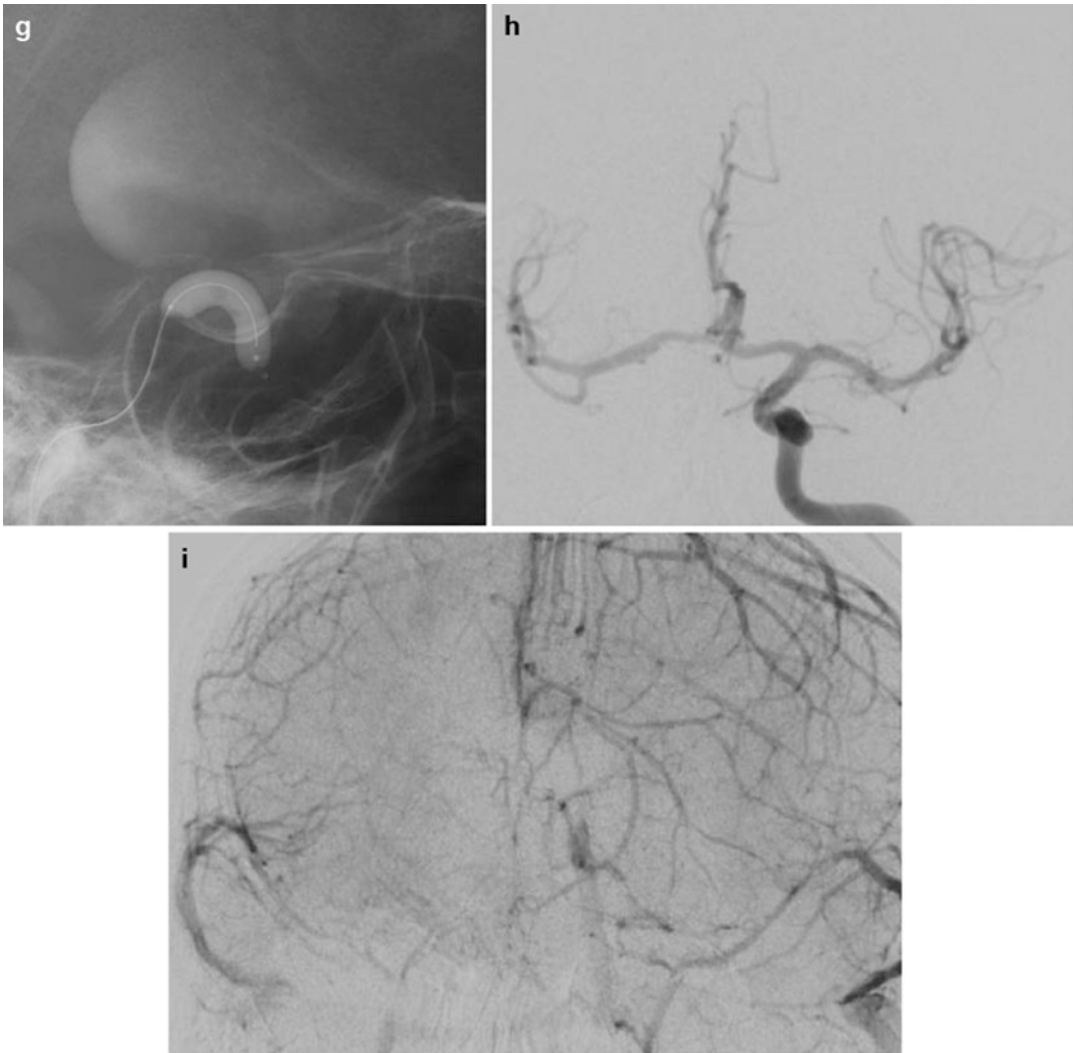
Diagnostic imaging in a symptomatic giant right-hand ICA/PcomA aneurysm. Axial (a), coronal (b), and sagittal (c) T2WI MRI showed a giant aneurysm of the right ICA surrounded by minor gliosis and with no calcification of the aneurysm wall. Baseline DSA (posterior-anterior projection (d), lateral projection (e), 3D reconstruction from rotational DSA images (f)) showed
